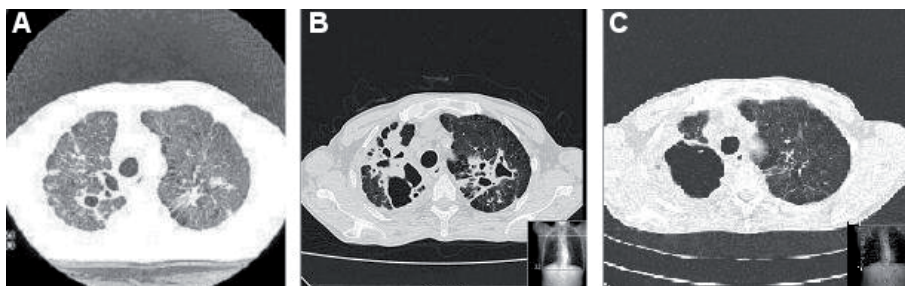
The patient's CT images
